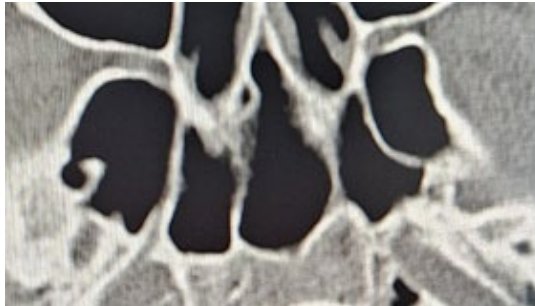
Axial CT slice of the sphenoid sinus, bone window, demonstrating a multiseptate sinus with four complete septa and one incomplete septum
